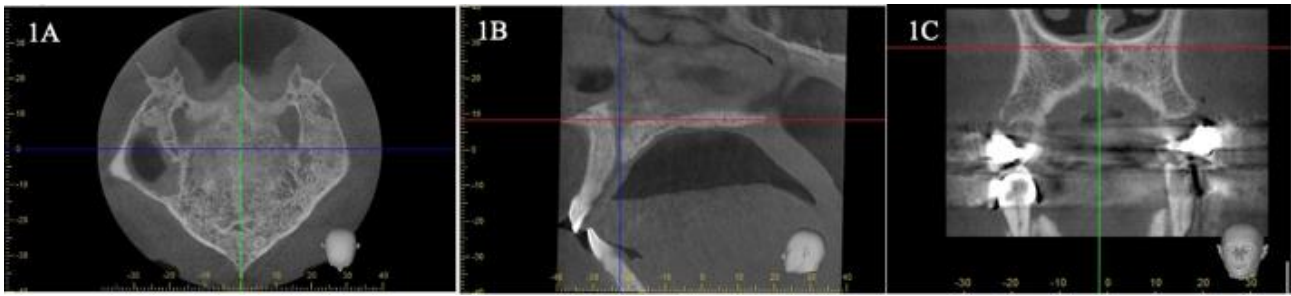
Standardisation of images in CBCT slices.
